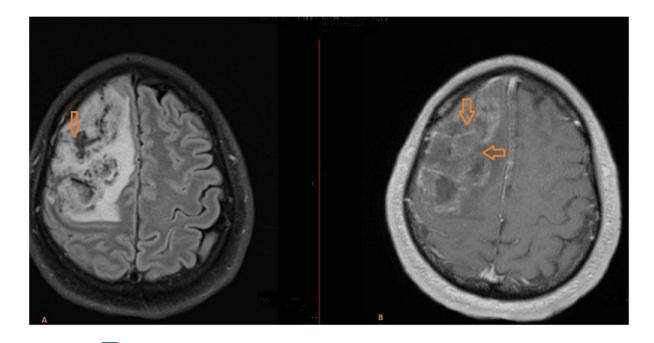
(A) Fluid-Attenuated Inversion Recovery (FLAIR) and T1-W post-contrast Images (B)
